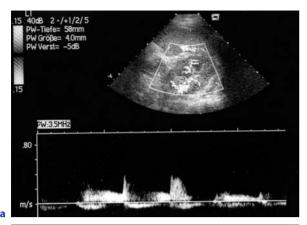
Sonographic findings in lupus nephritis. a Unspecific changes of the renal parenchyma with reduced vasculature on color Doppler sonography and increased RI (peripheral RI = 0,75) on duplex Doppler in acute severe lupus nephritis. b Normalization of renal vasculature on amplitude-coded color Doppler sonography with improvement of peripheral RI during treatment (prior to clinical normalization)
